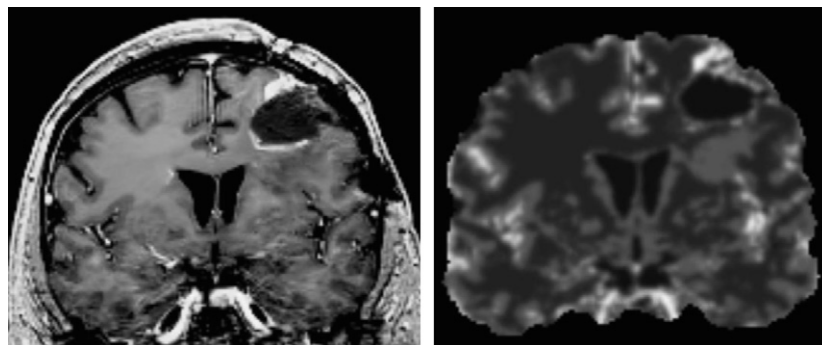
Left: MR image of the head. Right: Corresponding pseudo-ultrasound of the brain.
